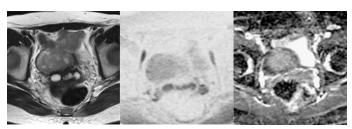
Malignant lymphoma: a. T2WI; b. DWI; c. ADC map, Myometrial mass shows very high intensity on DWI with low ADC (0.56).
